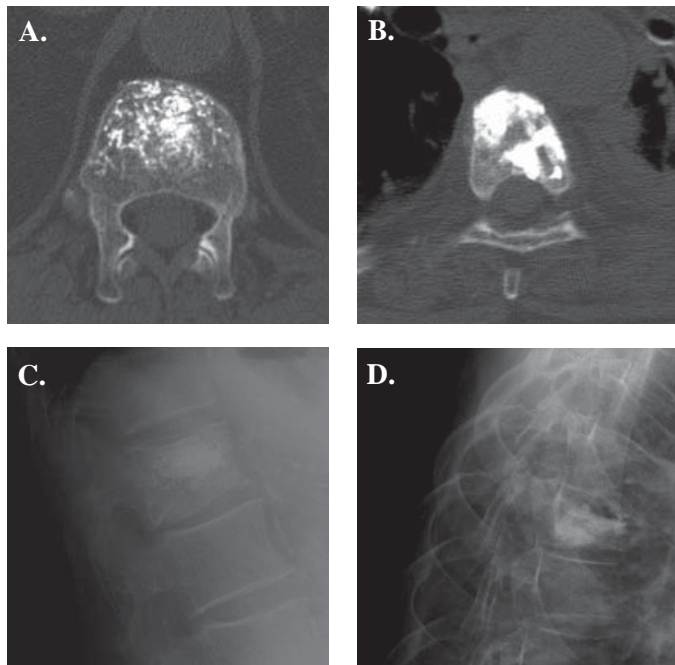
The post-operative axial CT and lateral X-ray images clearly show the more interdigitated fill pattern in the vertebral body treated with Cortoss (A & C) versus the more bolus fill with PMMA (B & D).
